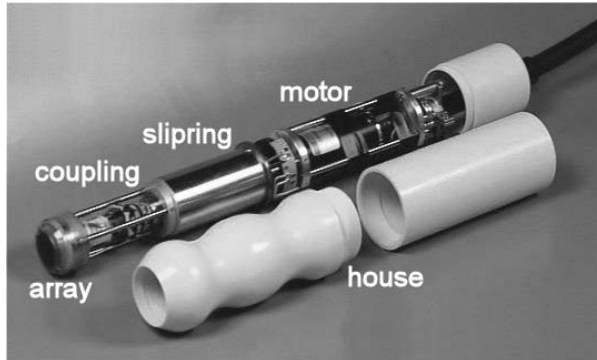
Figure i.2: Construction of the fast rotating ultrasound transducer, second prototype.
